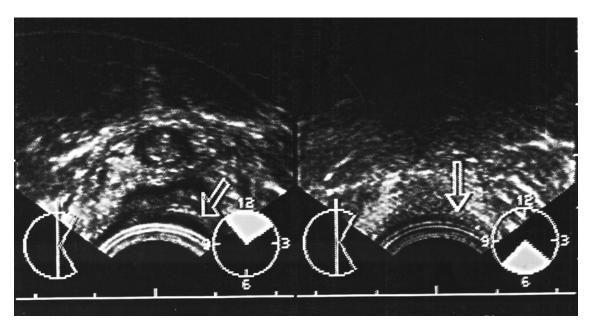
Endo anal ultrasound of a 6-year-old child with anorectal incontinence after abdominoperineal pull-through for congenital ARM showing defect of the sphincteric complex in more than half of the circumference.
